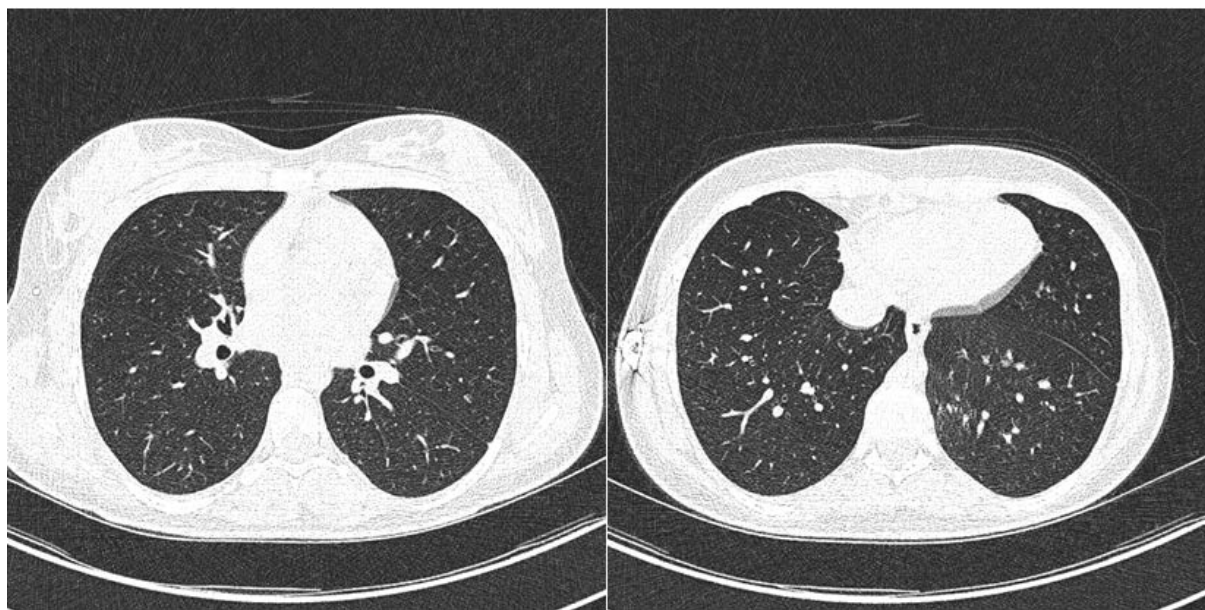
HRCT images at age 12.5
